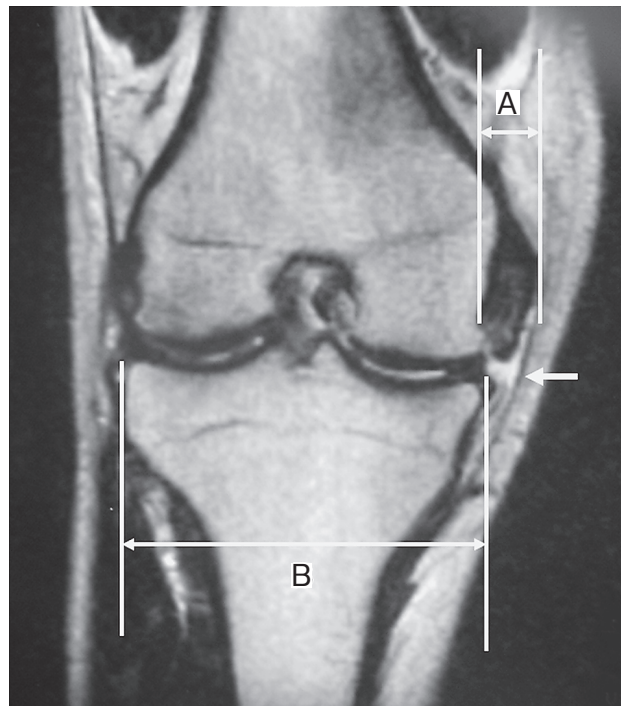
This 16-year-old male suffered MCL and ACL injury while playing rugby football and his knee showed Grade 3 instability by the Hughston and Eilers classification. This MRI shows the T2-weighted image. A, the maximum transverse diameter of the area of hemorrhage and swelling; B, the maximum transverse diameter of the articular surface of the tibia. White arrow shows discontinuity of MCL and leakage of articular fluid.
